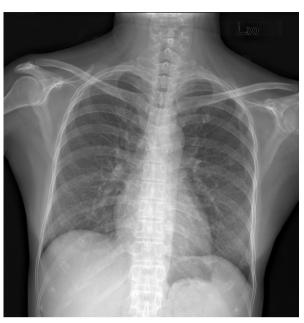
Chest radiography revealed miliary shadows at the bilateral lung area
